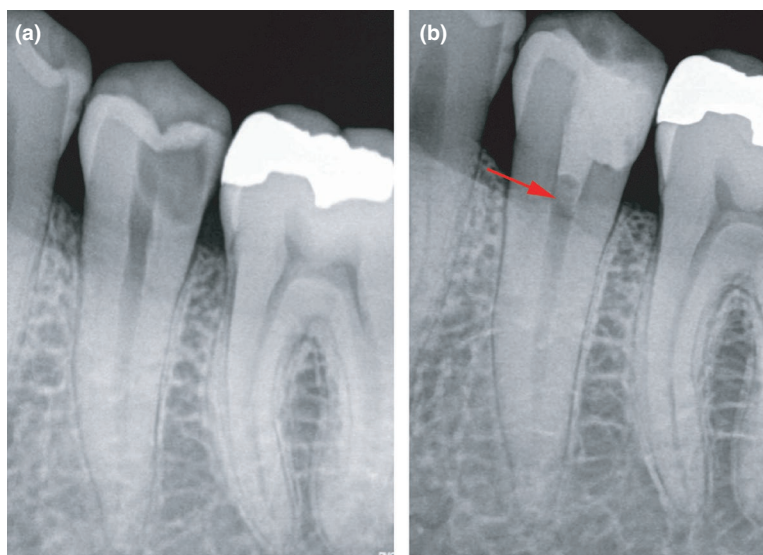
Lower left second premolar presented with moderate (irreversible) pulpitis treated with partial pulpotomy using Biodentine™. (a) Preoperative periapical radiograph of the tooth with coronal radiolucency indicative of extremely deep caries. (b) Twelve-month radiographic evaluation showing hard tissue bridge formation (red arrow). The tooth responded positively to pulp sensibility testing and was asymptomatic
